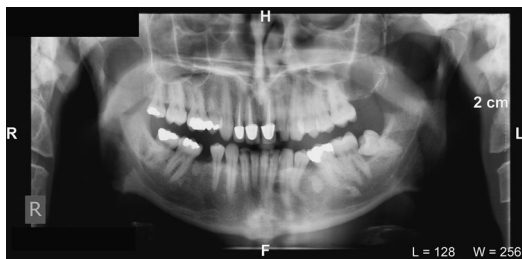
Panoramic radiograph shows well-circumscribed radiolucent lesion apical to the first molar tooth.
